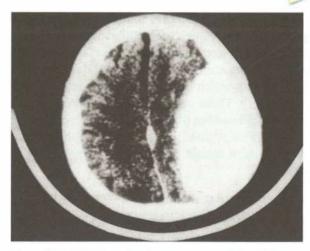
CT scan showing extradural haematoma
